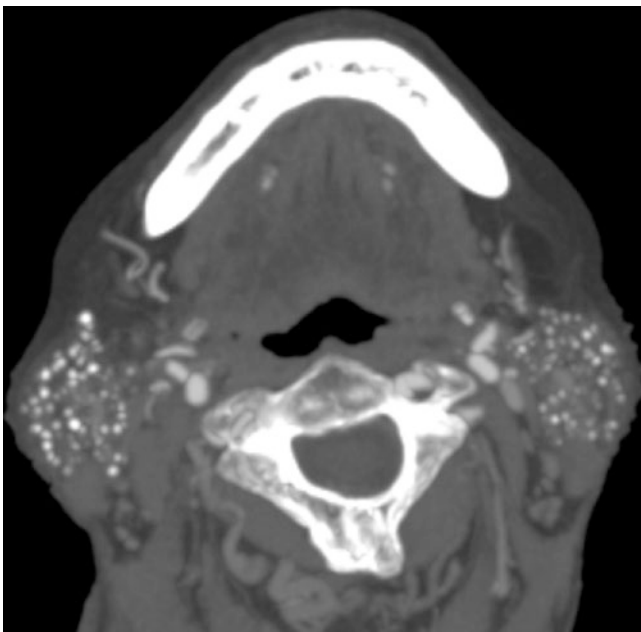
Sjögren's syndrome; 80-year-old female with long history of disease. Axial post-contrast CT image (from CT angiography) shows multiple punctate calcifications in parotid glands, bilaterally
